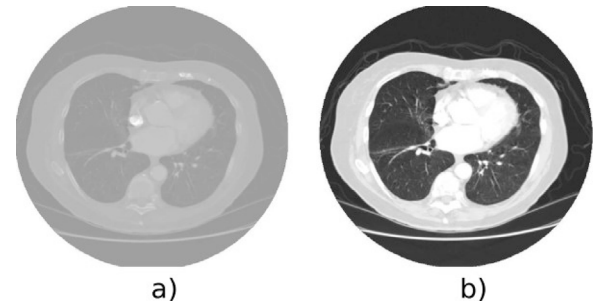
Demonstration of preprocessing of a chest CT scan. (a) Original image, (b) Preprocessed image in which the artifacts are removed by applying filters and increasing contrast of the image to achieve better quality.
